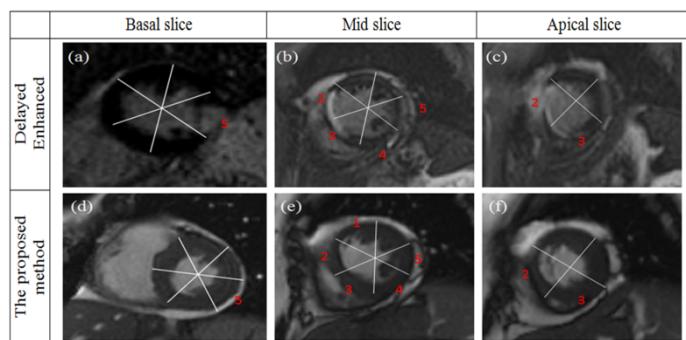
Comparison between infarcted regions using LGE MRI (a,b and c) and regions with motion abnormality detected using the proposed method (d,e and f).
